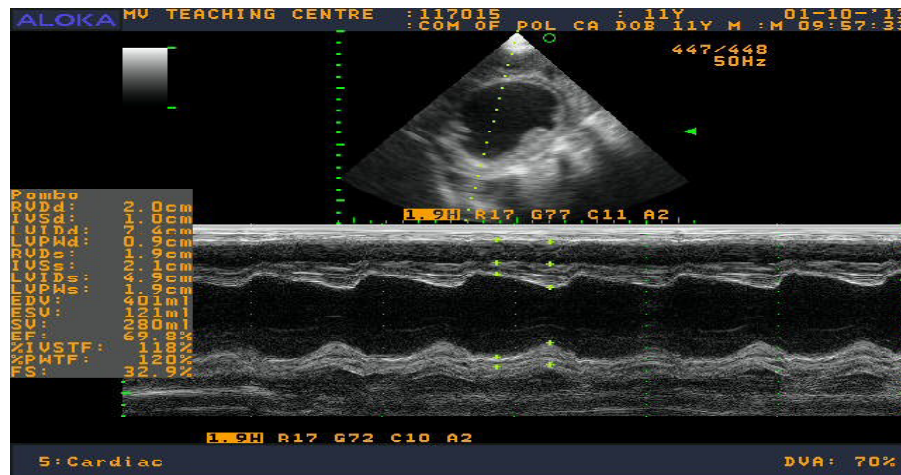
Echocardiographic findings with cmvi.
